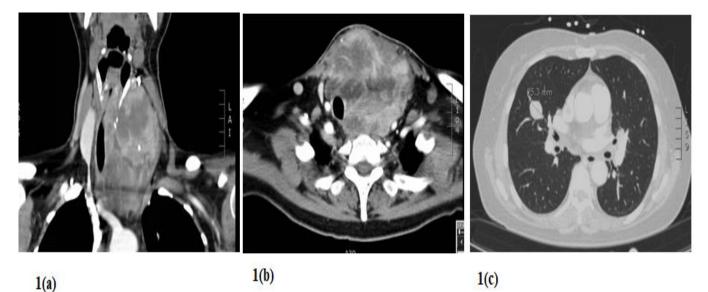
Neck CT scan showing a large thyroid mass present in the left side of the neck with hemorrhage encroaching the trachea and pushing it to the right side (A and B, arrows); contrast chest CT showing bilateral pulmonary nodules (C, arrows), consistent with lung metastasis.
